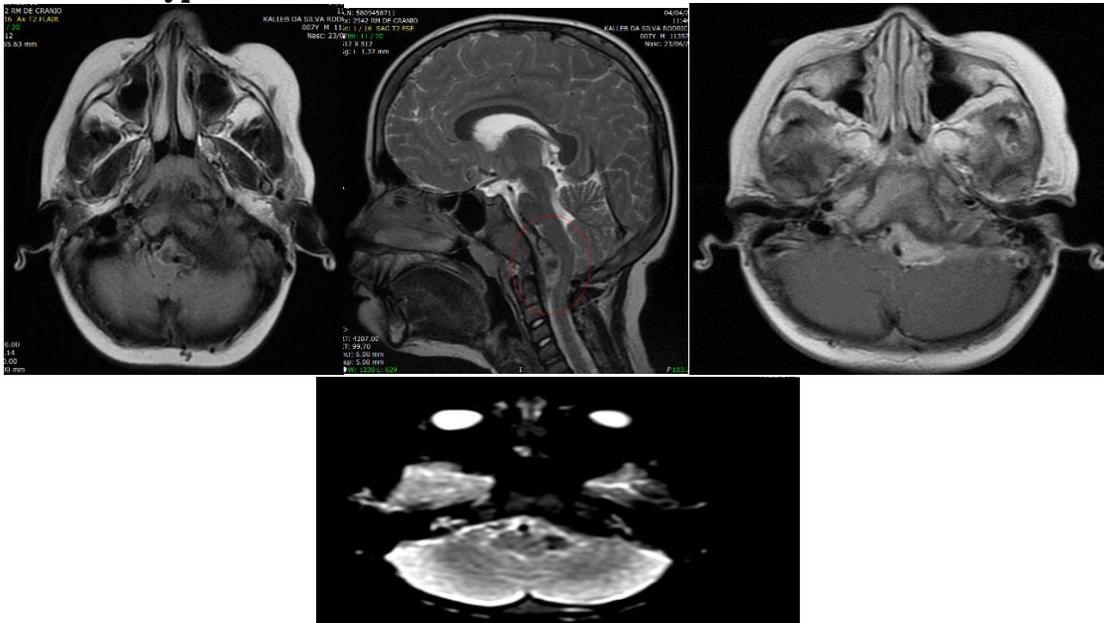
A, axial T2 FLAIR; B, sagittal T2 FSE; C, post-contrast T1; D axial DWI, show solid extra-axial expansive formation (arrows), with diffusion restriction and intense contrast enhancement, located in the craniocervical transition to the left, compressing the ventrolateral face of the medulla and cervical spinal cord, compatible with meningioma. Imaging findings in a 7-year-old male patient with seizures, facial paralysis and skin patches.
